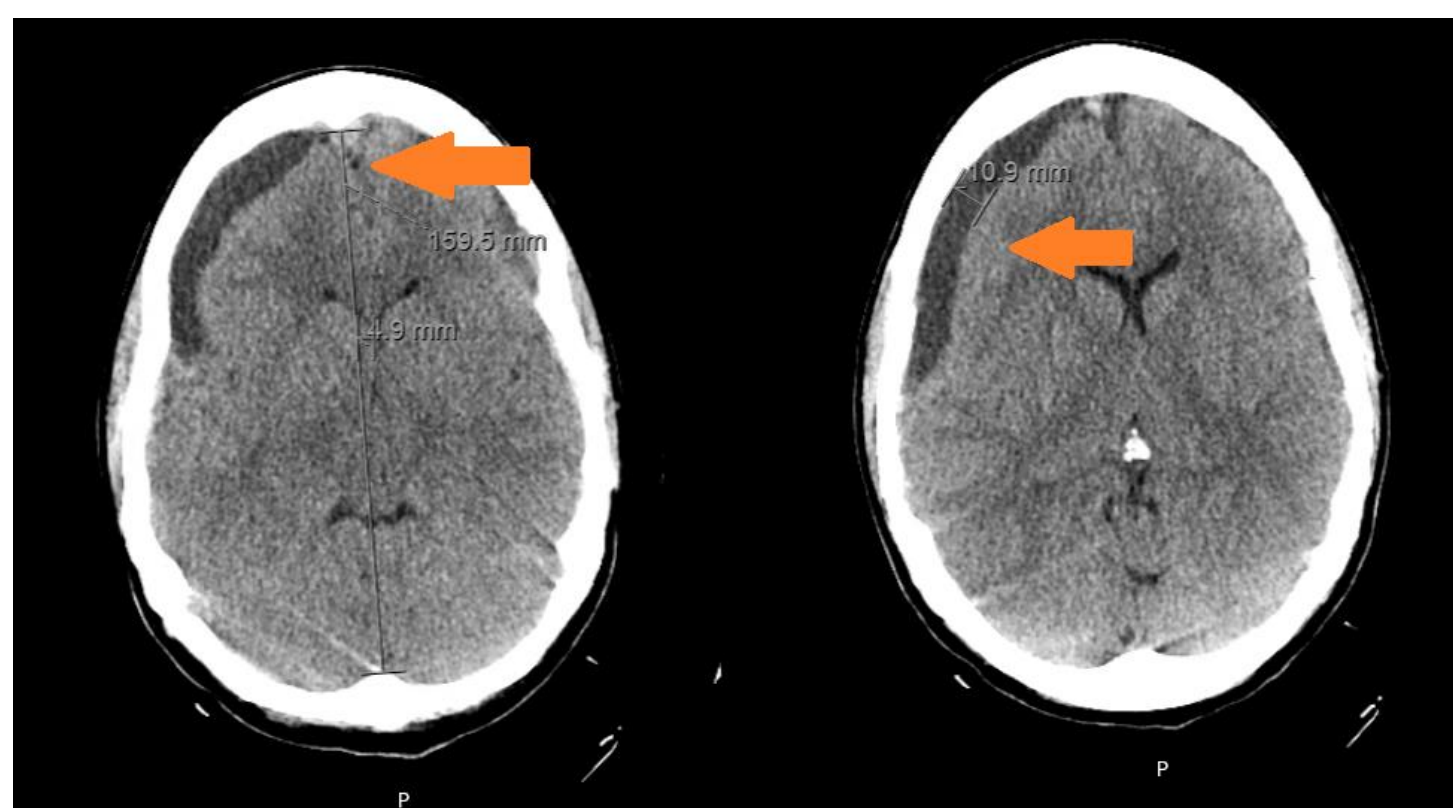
CT brain with (right to left) midline shift and subdural hemorrhage
